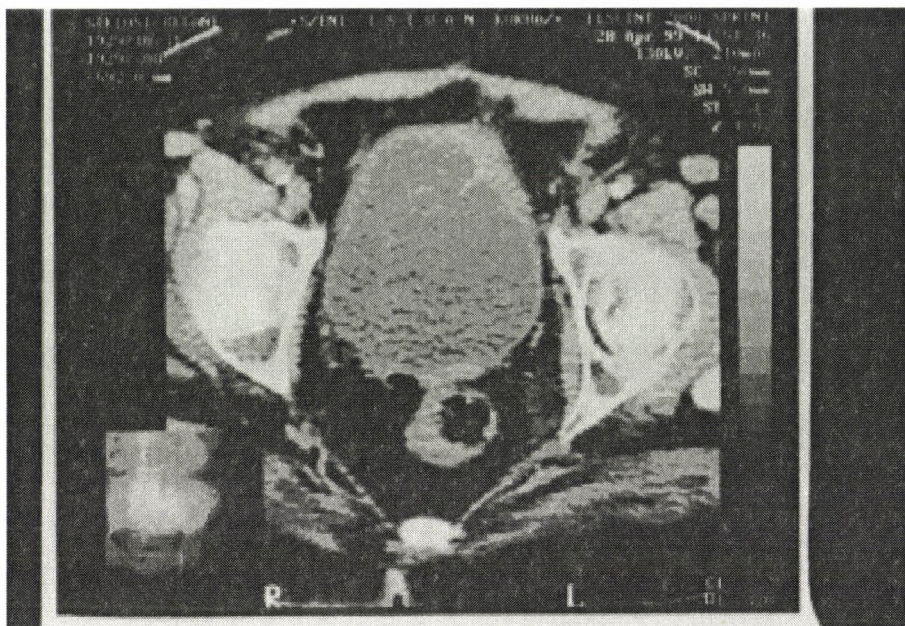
By computed tomography the bladder wall is seen to be concentrically thickened, particularly in the posterior left section
